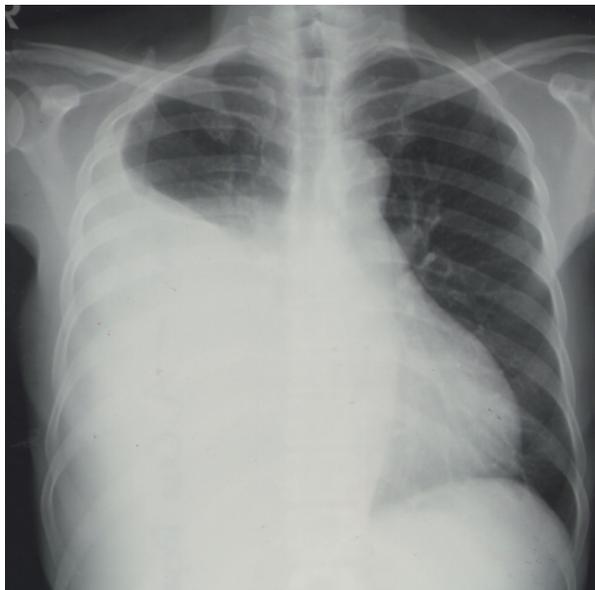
Chest X-ray showed a massive amount of right-side pleural effusion.
